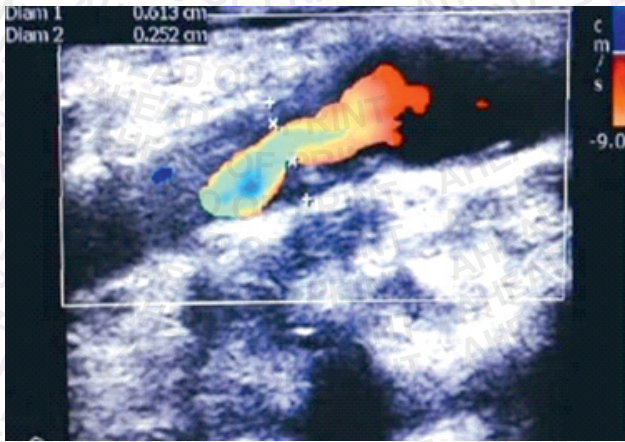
Colour Doppler images showing reduced colour flow with heterogeneously hyperechoic plaque in Left ICA causing 58.9 % area stenosis
